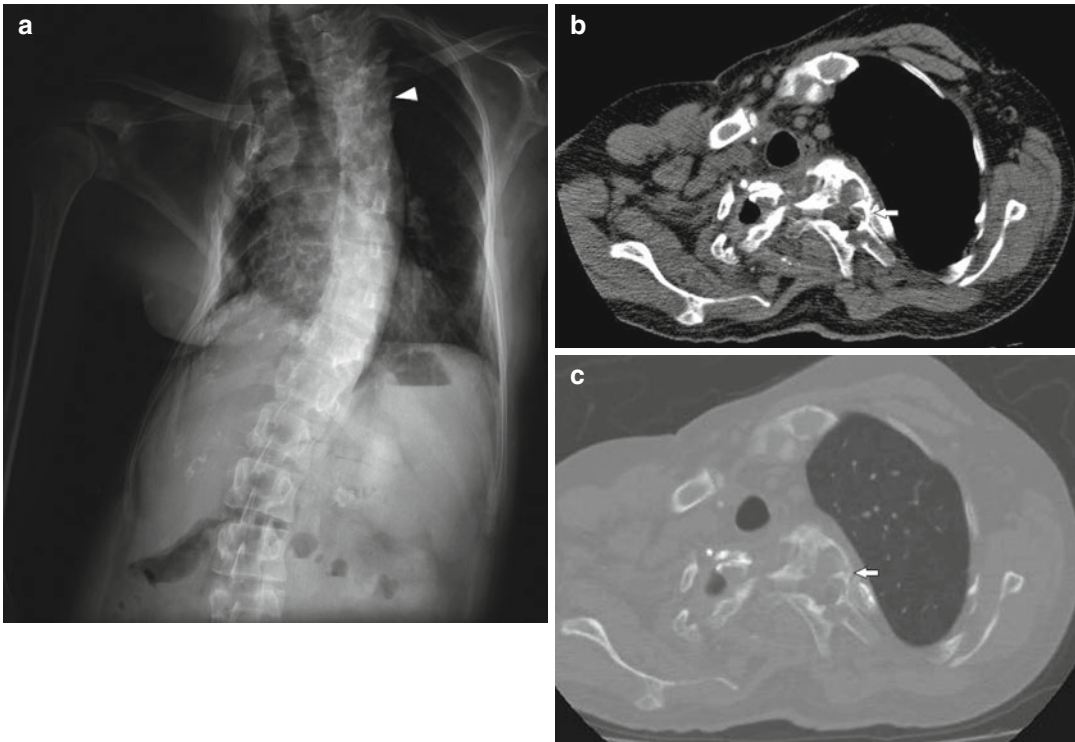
Anteroposterior plain X-ray (a) of a 54-year-old male patient with thoracic spinal hydatid disease. There is marked kyphoscoliosis (*arrowhead*). Subtle radiolucent areas can be seen in the upper thoracic vertebrae. Unenhanced axial chest CT images with soft tissue window
